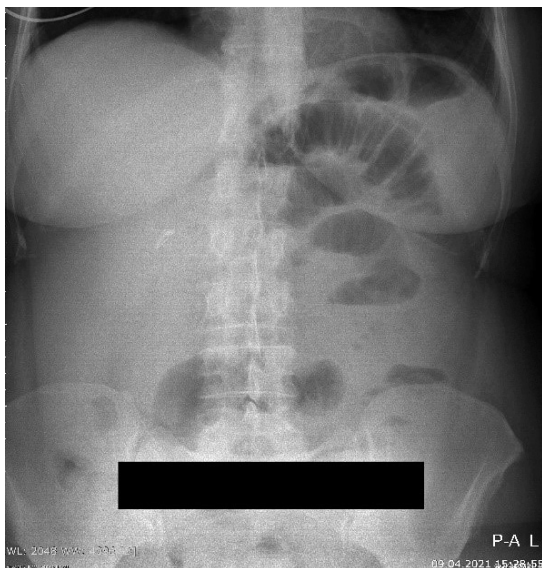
Plain abdominal X-ray with small bowel air-liquid levels
